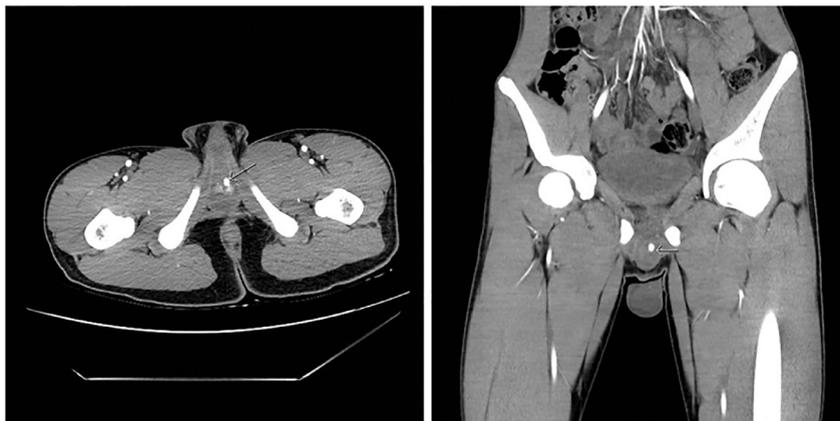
Axial and coronal images from contrast-enhanced CT angiogram in arterial phase demonstrating a focus of active contrast extravasation (arrow) in the bulbous urethra arising from a branch of the left pudendal artery. CT, computed tomography.
